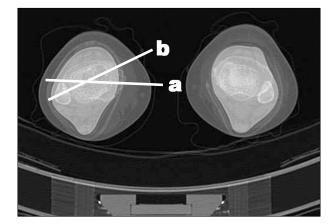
Computed tomography of right tibia, which measures the angle between the bisection line of tibia head (a) and the line connecting medial and lateral malleolus at distal tibia (b).
